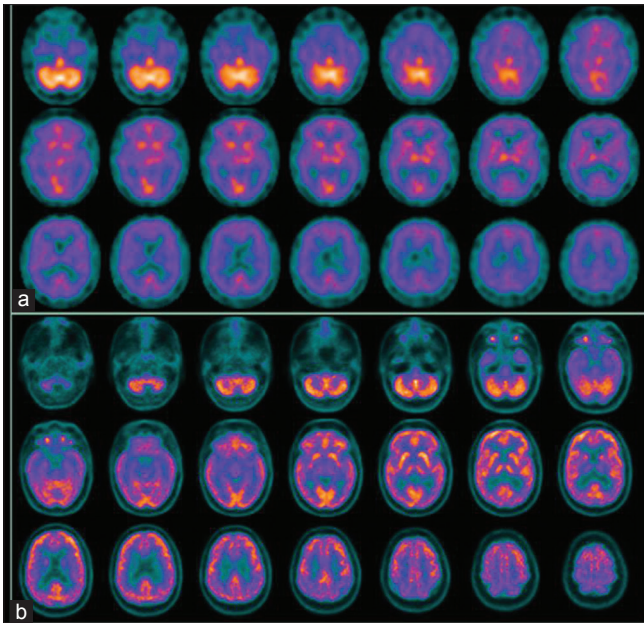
Brain perfusion single-photon emission computed tomography (a) and ^{18}F -fluorodeoxyglucose-positron emission tomography (b) performed 4 months after the stroke event and another 2 weeks, respectively. Transaxial images in three upper files (a) showing relative moderate hypoperfusion of the brain lobes, more marked in temporoparietal cortex. The cerebellum shows a relative elevated perfusion. In the three lower files (b), we see transaxial slices of ^{18}F -fluorodeoxyglucose-positron emission tomography showing conserved metabolism in the brain lobes with only a slightly increase in the cerebellum
